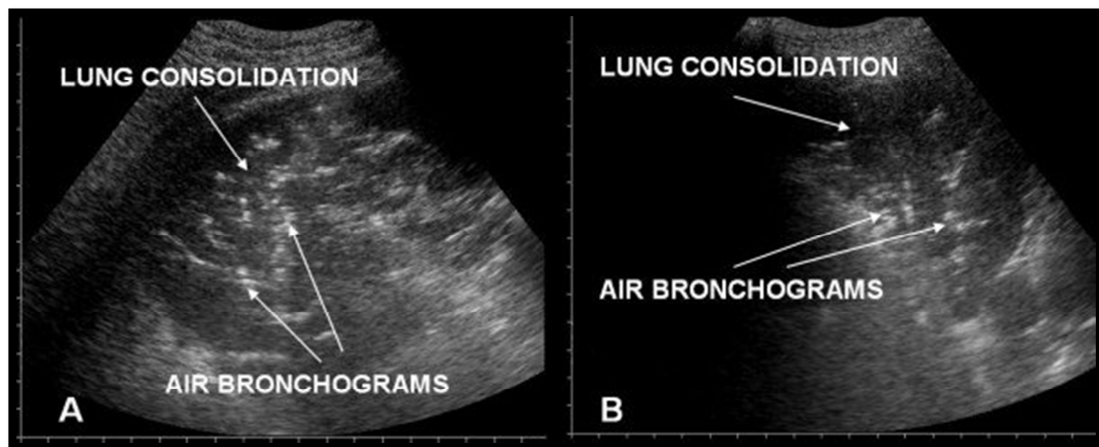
Lung ultrasonography demonstrating consolidation
